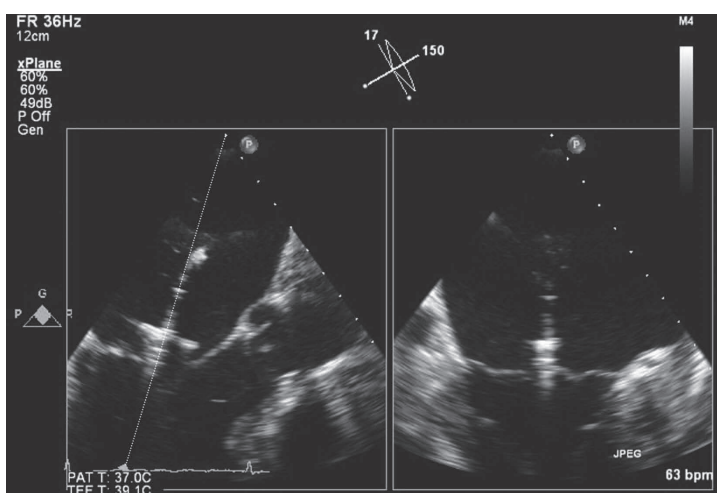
MitraClip monitoring. iRotate of 150° with lateral tilt of 17° during transesophageal echocardiography allowing continuous monitoring of the positioning and deployment of the mitral clip.
